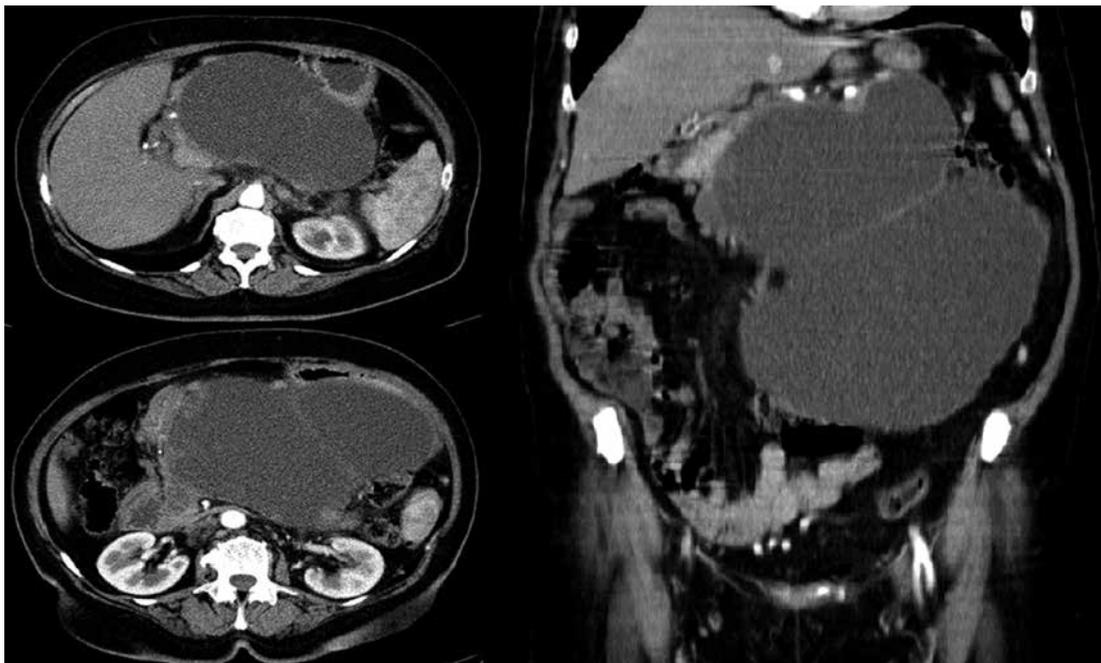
Contrast-enhanced computed tomography of the abdomen performed before the treatment
